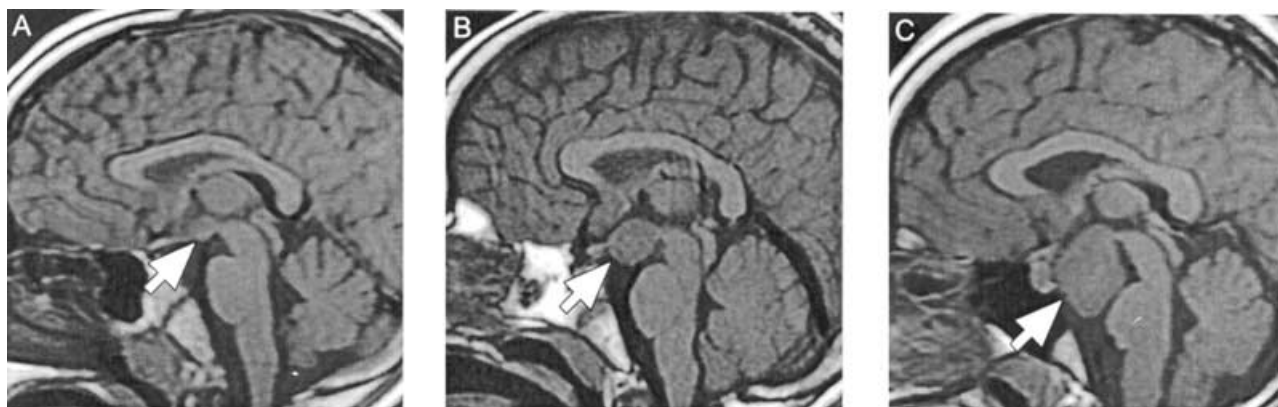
Sagittal magnetic resonance imaging (MRI) scans showing hypothalamic hamartomas of different sizes. A: A small lesion in the third ventricle (8 mm diameter) in a 10-year-old girl seen with gelastic seizures at age 2 years. Such lesions can be easily missed on a cursory examination of MRIs. B: An intermediate lesion (17 mm diameter) in a 5-year-old boy seen with neonatal-onset gelastic seizures, followed by complex partial and tonic–clonic seizures and associated with developmental delay and aggressive and autistic behavior. C: A large lesion protruding well down into the interpeduncular and prepontine cisterns (34 mm maximum diameter) in a 14-year-old girl seen with gelastic and complex partial seizures associated with mild intellectual and memory impairment, but no behavioral disturbance.
